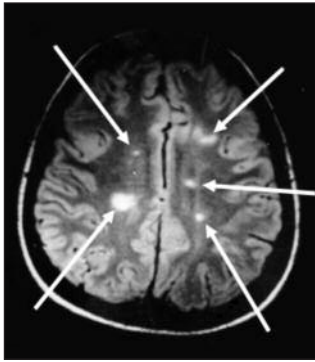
Axial section of MRI of the brain with gadolinium enhancement
